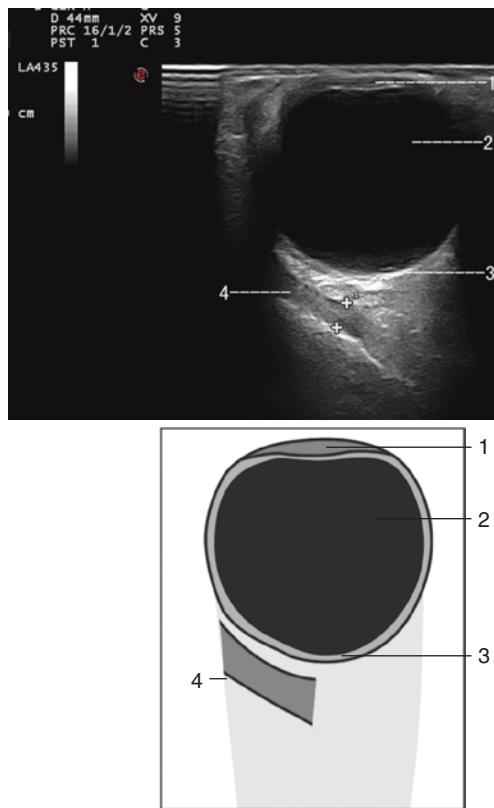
Normal sonogram of the extraocular muscles. Note: 1 cornea, 2 vitreous body, 3 eyeball, 4 extraocular muscle
